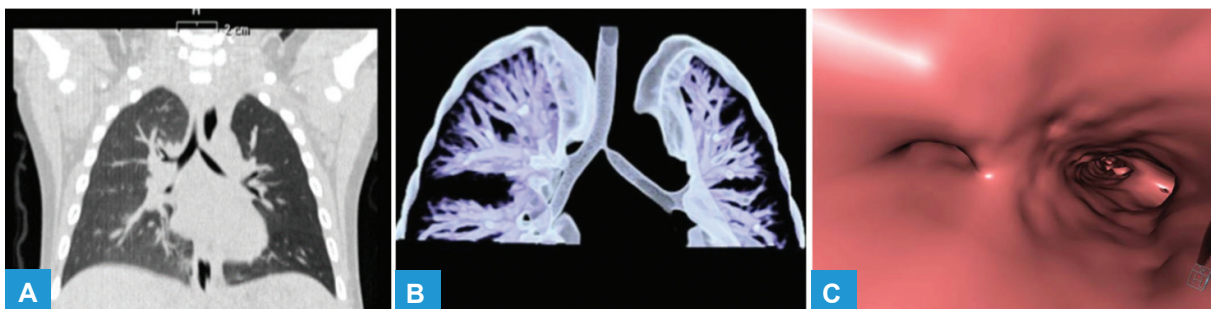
(A) Coronal non-enhanced CT image with lung window showing stenosis of the proximal left main bronchus and hyperinflation of the right lung; (B) 3D volume rendering reconstruction of the tracheobronchial tree; (C) virtual bronchoscopy reconstruction demonstrating marked narrowing of the left main bronchus lumen.
